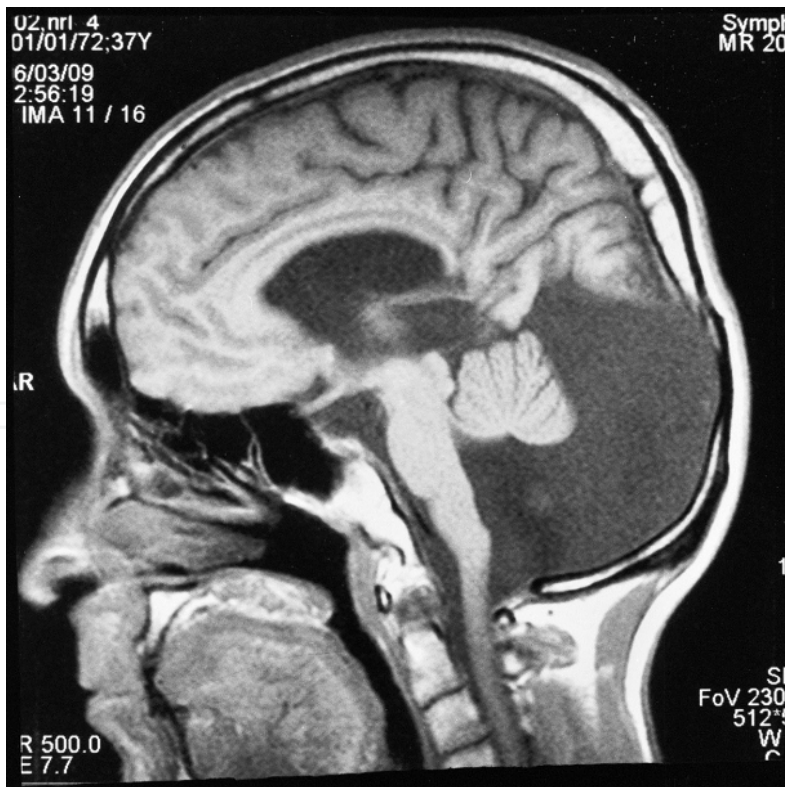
MRI of the brain: T1-weighted sagittal view shows Dandy-Walker malformation with enlarged posterior fossa because of the cyst, aplasia of the caudal part of the cerebellar vermis, and extensive IV ventricle communication with the cyst.
